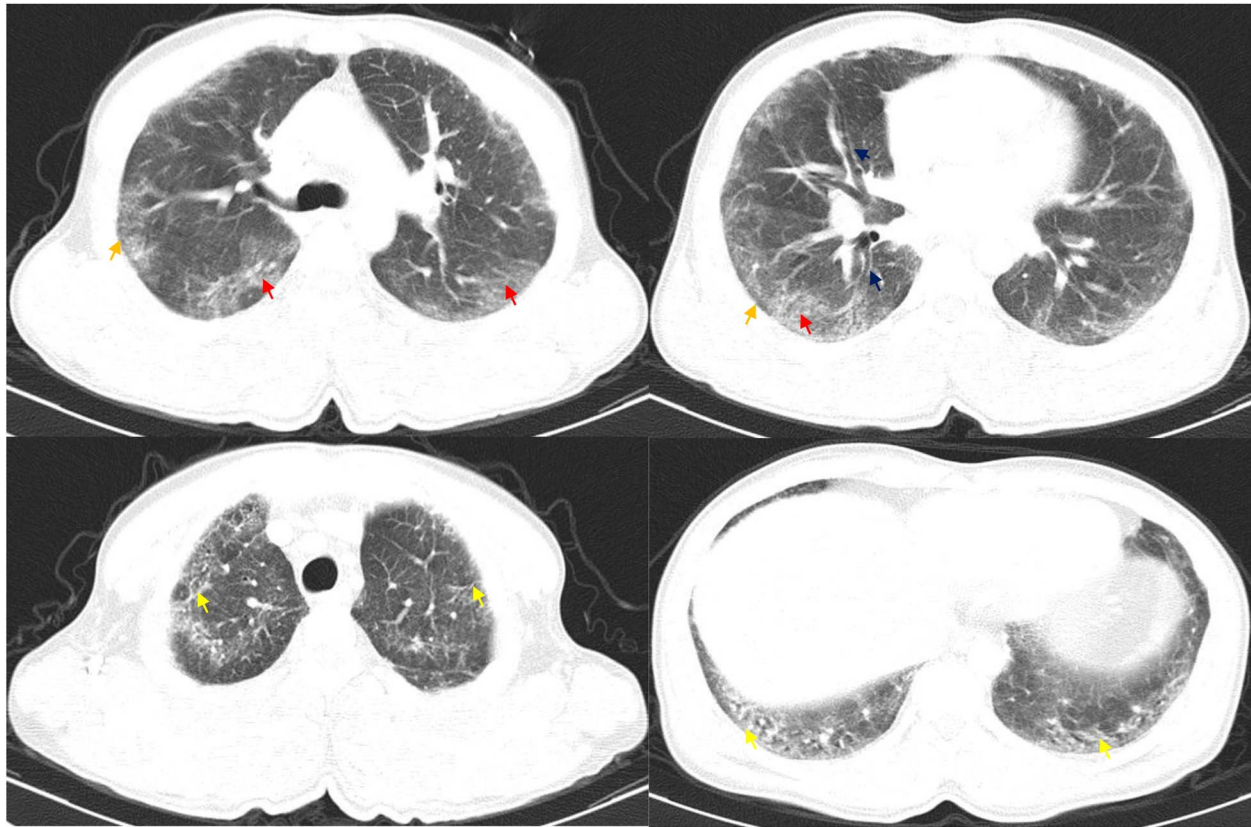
The patient's CT scan shows reticular patterns (yellow arrow), ground-glass opacities (red arrow), subpleural sparing (orange arrow) and bronchoalveolar bundles thickening (blue arrow). Findings are suggestive of the possible diagnosis of fibrotic NSIP.
